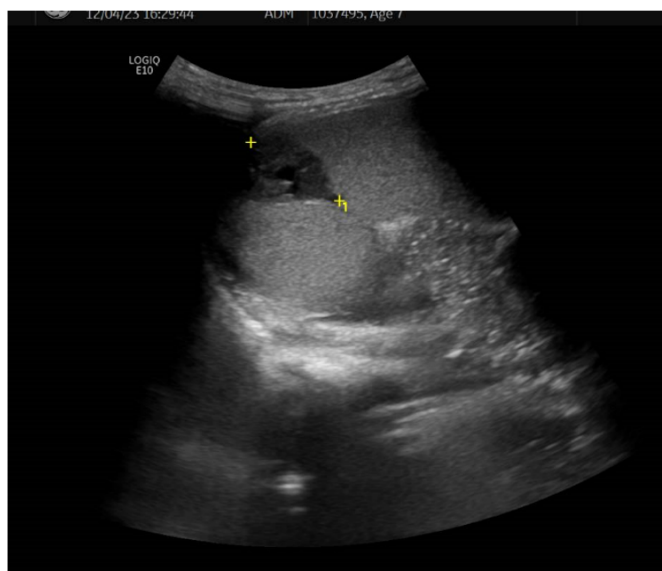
Abdominal ultrasound showing findings consistent with splenic infarction
